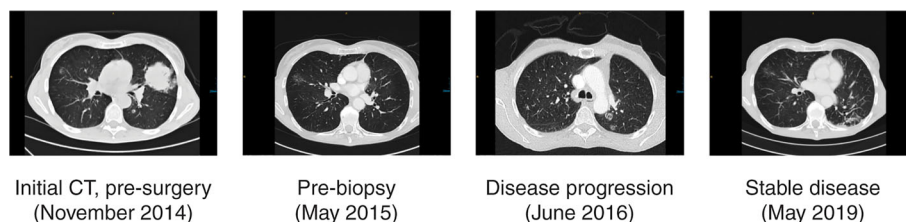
Patient 1 clinical course, including treatment history and CT scans. CT, computed tomography.
